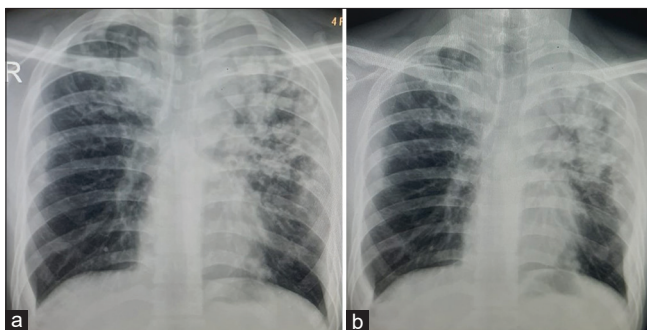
(a) Initial radiograph chest shows dense acinar radiopacities in the left upper zone, and superior part of left middle zone, suggestive of active pulmonary tuberculosis. (b) Radiograph chest obtained 04 months following institution of delamanid shows significant resolution of the lesions
